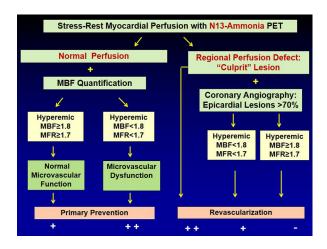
Algorithm for the integration of ¹³N-ammonia PET/ CT perfusion images and MBFs in multivessel CAD. In individuals with normal stress-rest myocardial perfusion images, the quantification of hyperemic MBF and MFR may unravel microvascular dysfunction as functional precursor of CAD that may reinforce lifestyle changes and/or preventive medical care. Conversely, while a stress-induced regional perfusion defect signifies the "culprit" or most advanced CAD lesion, added hyperemic MBF and MFR may signify flowlimiting effects of lesions >70% diameter stenosis in patients with multivessel CAD^{1,4}.
